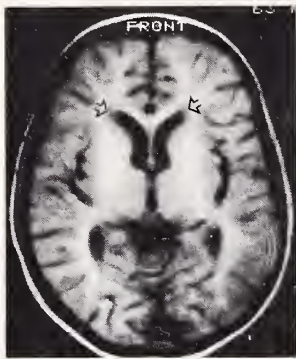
T1-weighted image revealing decreased signal intensity anterior and lateral to the frontal horns bilaterally.
